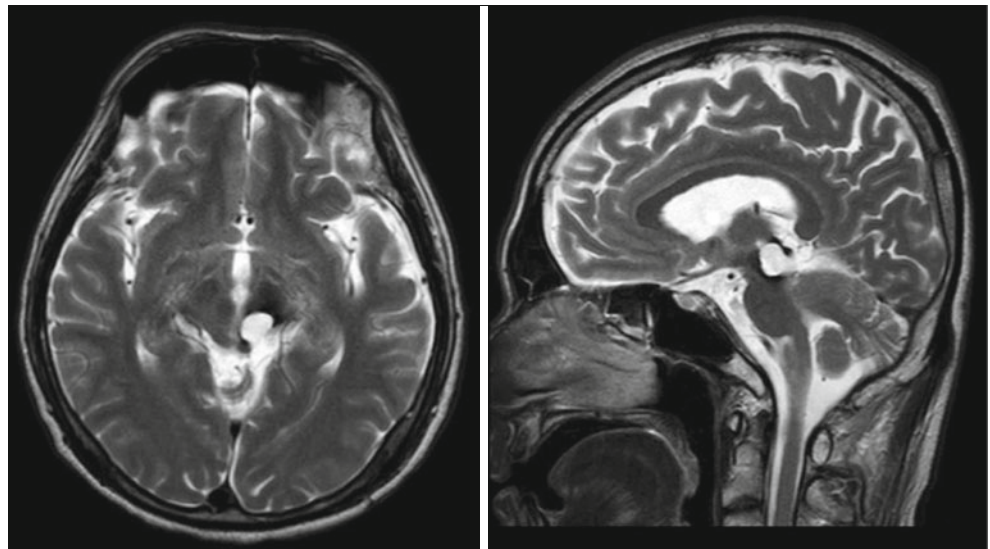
MRI showing a mixed intensity mass in the left mid-brain extending to the thalamus
